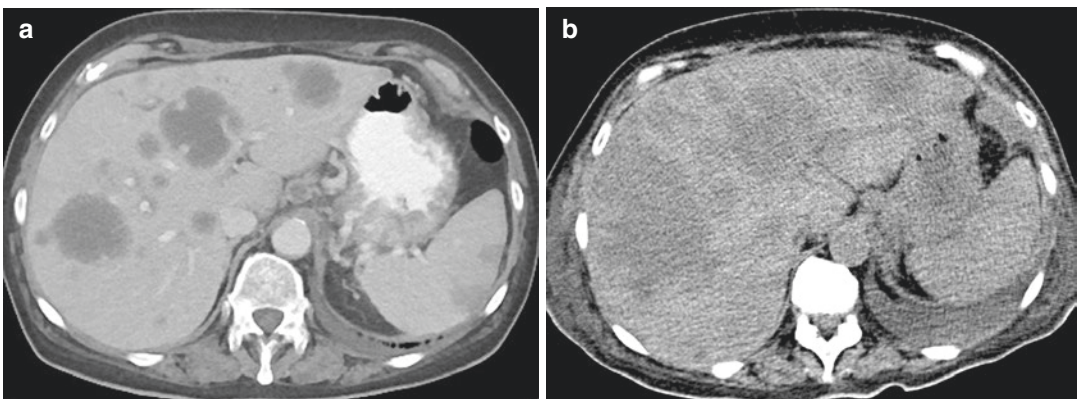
A patient with history of metastatic gastric cancer, previously treated with FOLFOX. (a) Axial contrast-enhanced CT shows primary tumor in the gastric fundus with multiple liver metastases and gastrohepatic ligament adenopathy. Trace left pleural effusion is present. (b) Axial noncontrast CT obtained at emergency department
